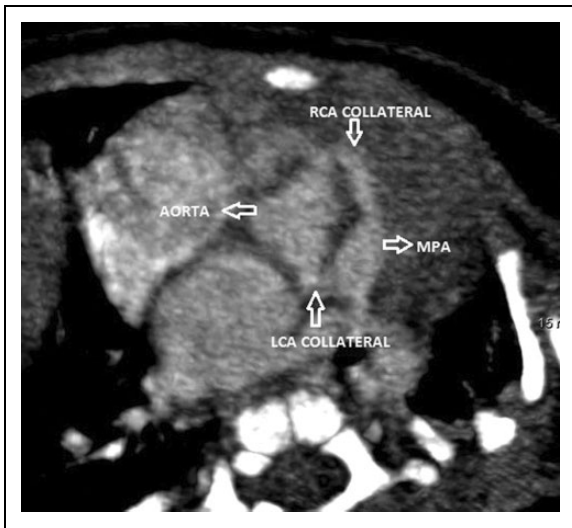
Cardiac computed tomography displaying collaterals from both the left coronary artery (LCA) and right coronary artery (RCA) to the main pulmonary artery (MPA).
